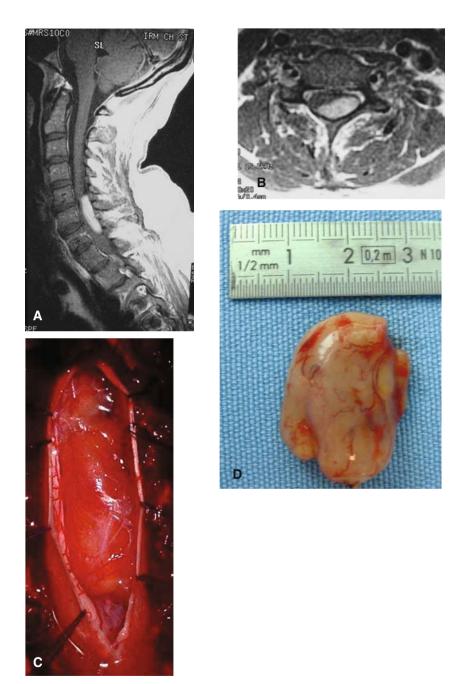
A Neurolipoma: sagittal T1-weighted MRI. B Axial T1-weighted MRI image. C Operative view. D After removal
